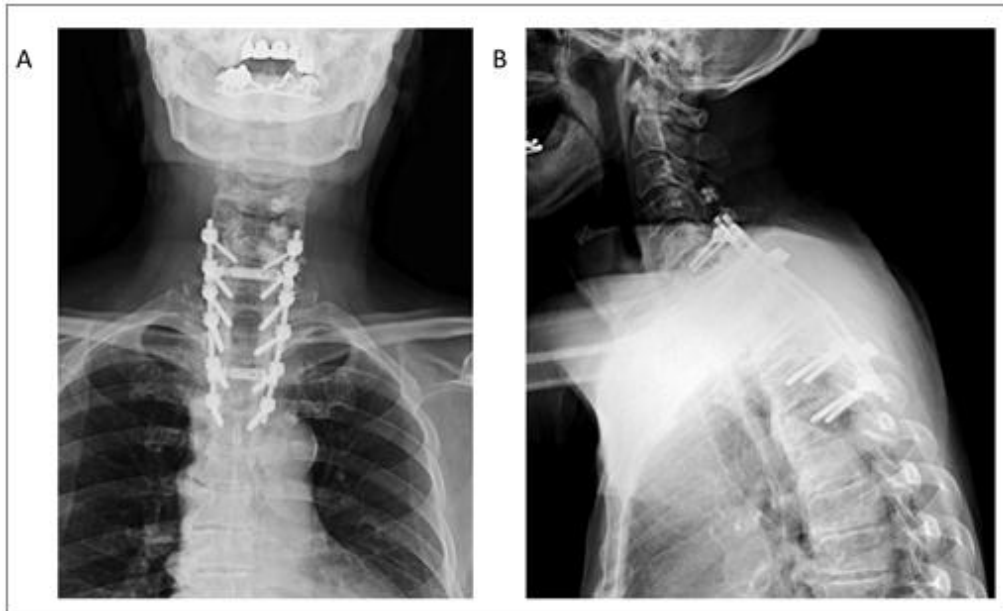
X-ray image of thoracic spine surgery following C6 to Th4 posterior fixation.
